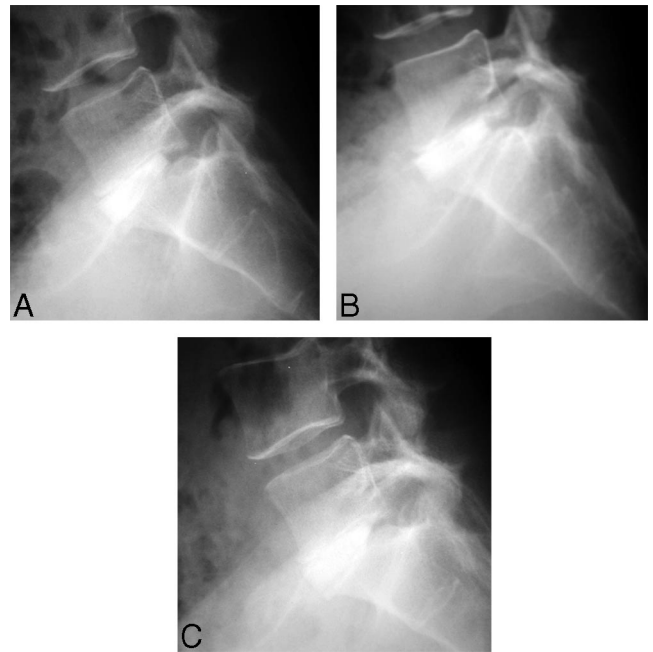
Sequential radiographs of ALIF with FRA and autogenous ICBG at various stages after surgery: 3 months (A), 6 months (B), and 18 months (C). Even when fusion criteria are met, the structural outline of FRA is still visible at later follow-up.
